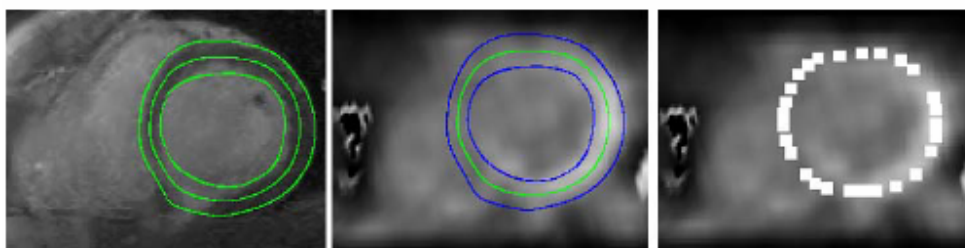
Calcul des valeurs de captation glucidique sur la surface médiane : (a) Intersection des surfaces endocardique (contour le plus interne), épiscopardique (contour le plus externe) et surface médiane calculée (contour intermédiaire) avec un plan de coupe IRM en petit axe, (b) les mêmes contours sont présentés dans l'image TEP-FDG recalée en PA correspondante (c) la valeur moyenne de la captation du FDG est calculée au niveau des nœuds de la surface médiane dans un voisinage de petite taille.
